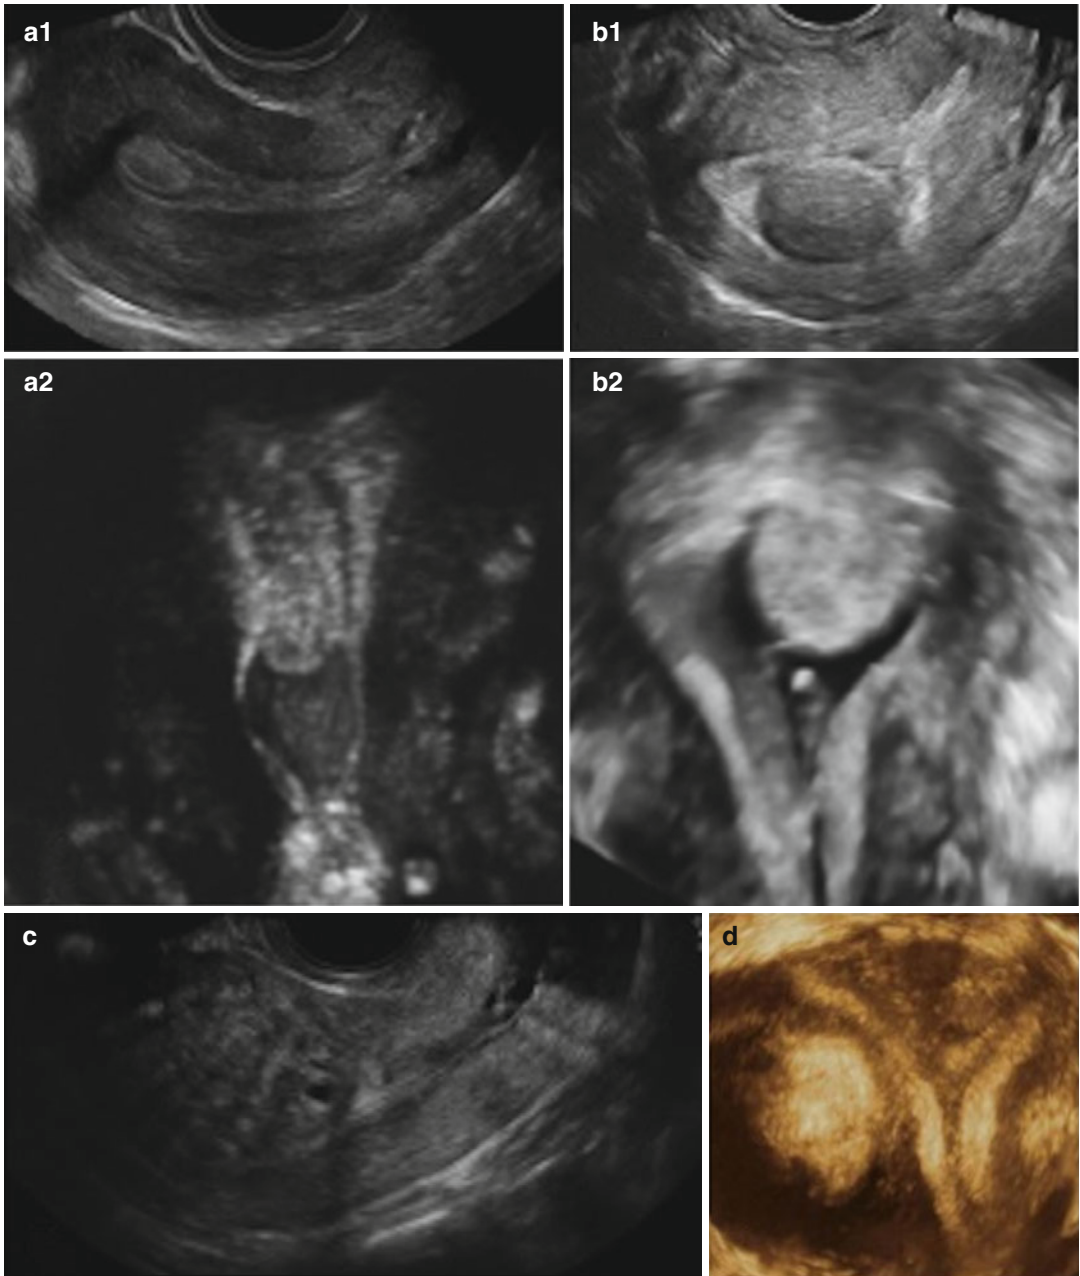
Ultrasound provides additional information on changes in uterine morphology. (a) endometrial polyp, polyp, (a1) 2D, (a2) 3D-FIS. (b) intracavitary fibroid, (b1)
